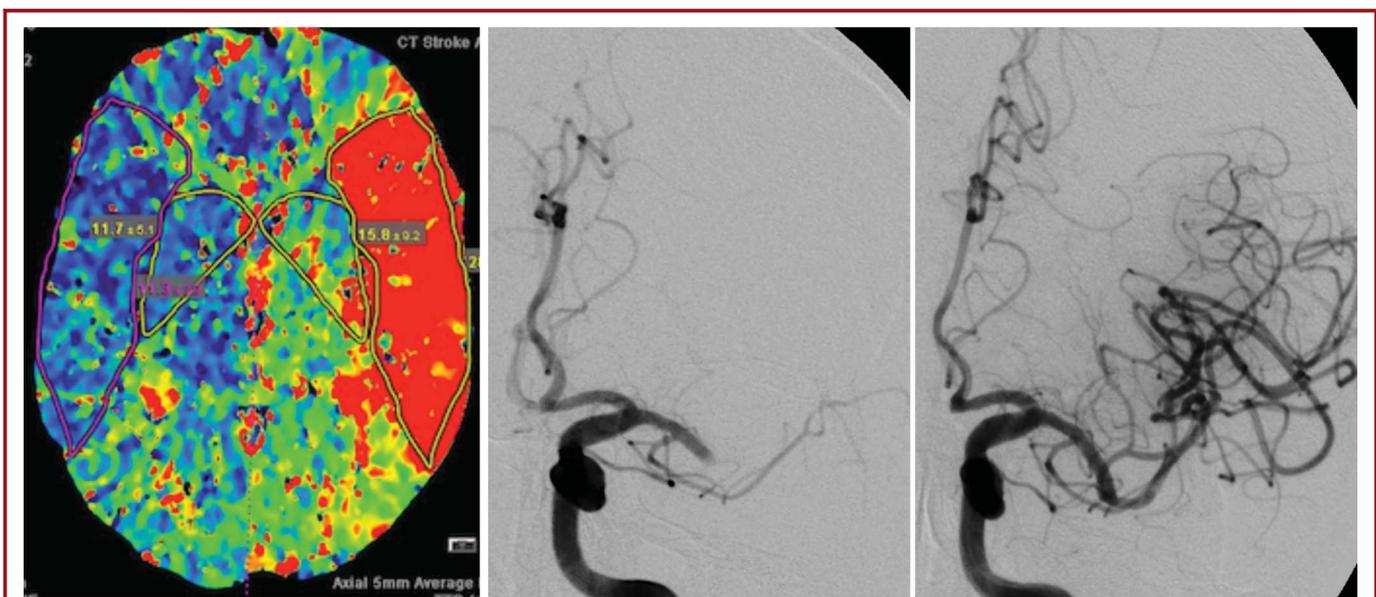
A case of acute stroke from the left middle cerebral artery occlusion. Left, computed tomographic perfusion image demonstrates a perfusion deficit within the left hemisphere. Middle, baseline angiography shows a cutoff within the M1 middle cerebral artery segment, indicating the site of the occlusion. Right, after successful thrombectomy with a stent retriever, complete recanalization and reperfusion of the left middle cerebral artery territory are achieved, corresponding to a Thrombolysis in Cerebral Infarction score of 3.
